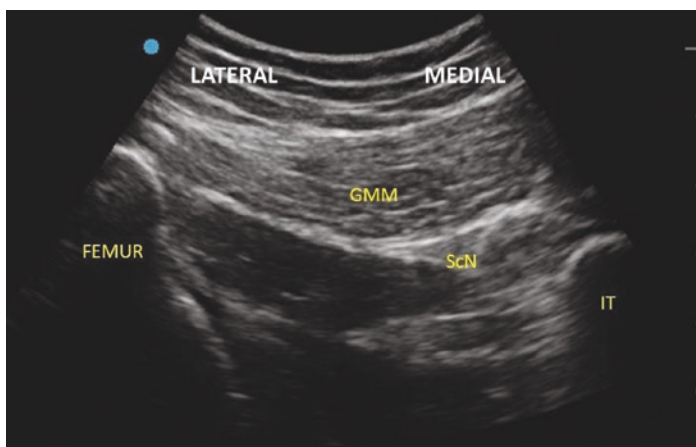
Sciatic nerve (transgluteal approach) ultrasound. The Sciatic Nerve (ScN) is a triangular shape deep to the gluteus maximus muscle (GMM) between the femur and the ischial tuberosity (IT)
